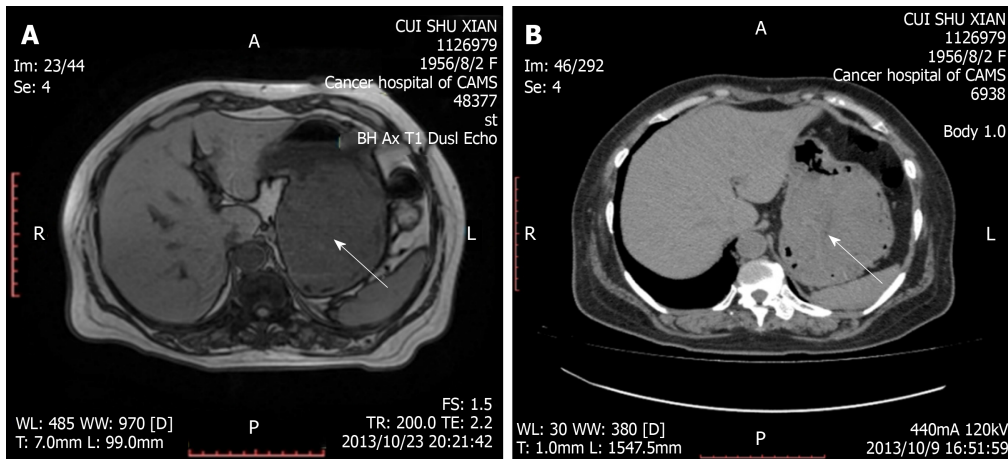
Magnetic resonance imaging and computed tomography confirmed a giant tumor in the stomach (arrow). A: Magnetic resonance imaging; B: Computed tomography.
